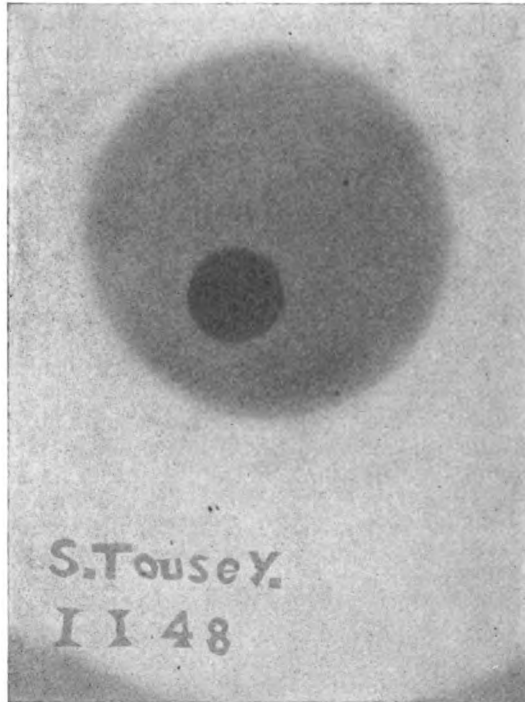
Radiograph of penny produced by secondary rays in the shadow of a silver dollar.
